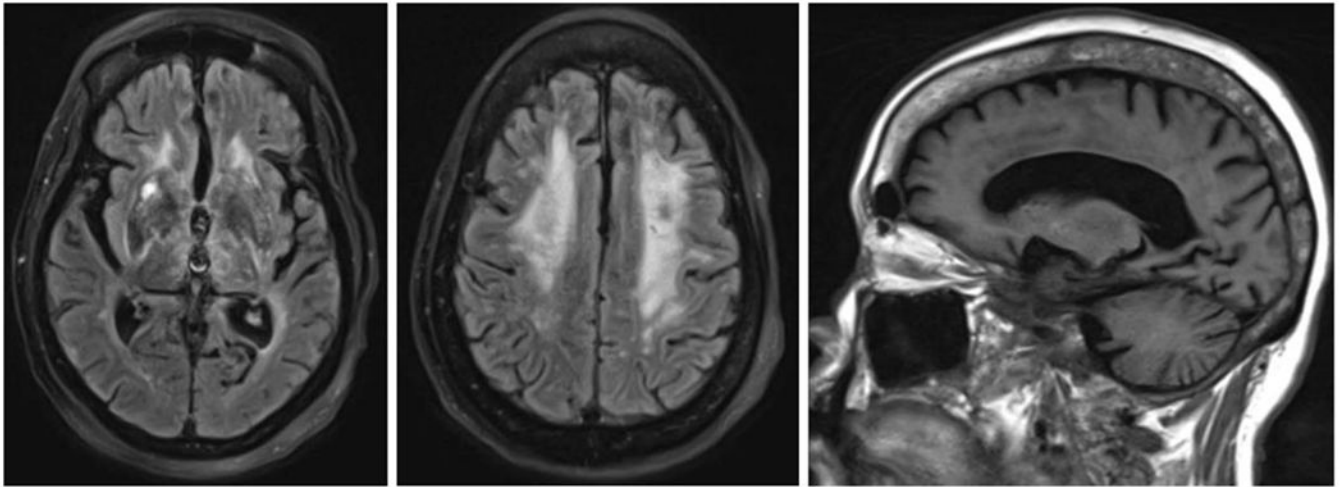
Index kidney recipient MRI brain with and without contrast eight months post-transplantation
